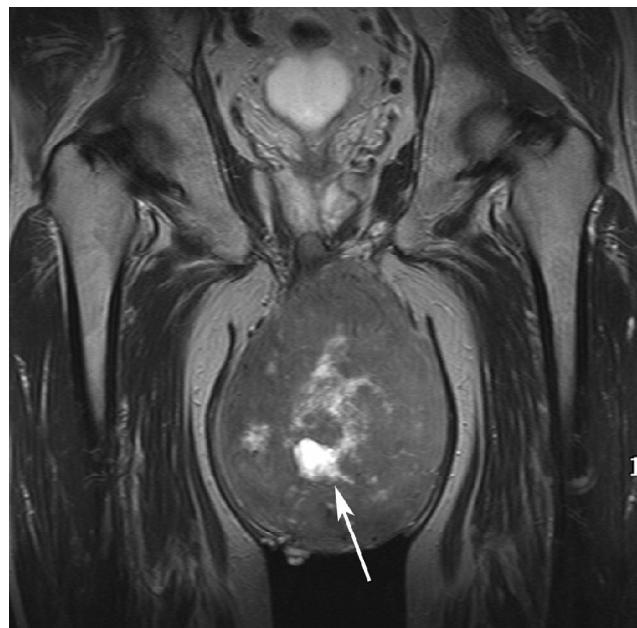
Coronal T2 weighted MR image of the pelvis shows a large mass with heterogeneous signal intensity in the scrotum. A focal necrosis (arrow) is seen with high signal intensity at the center of the mass.
